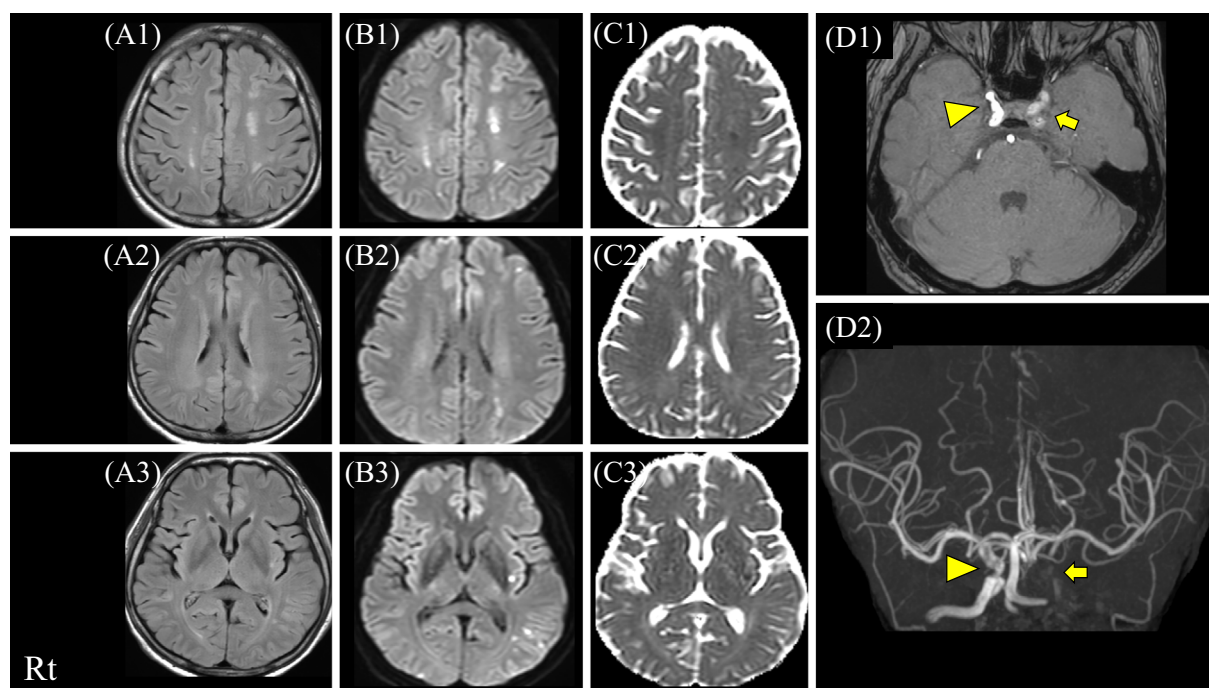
MRI of the brain (axial DWI, ADC, and FLAIR), and MRA performed after admission. (A1-3, B1-3) FLAIR and DWI show hyperintense lesions in the bilateral watershed areas between the anterior, middle, and posterior cerebral artery territories, which are predominantly distributed in the left hemisphere. (C1-3) The ADC values of the lesion are slightly lower in the left hemisphere than in the right. (D1) MRA depicts occlusion in the left ICA (small arrow) and slight stenosis at the siphon of the right ICA (arrowhead). (D2) The left ICA is invisible on reconstruction of MRA images (small arrow). The stenosis of the right ICA is also observed at the siphon (arrowhead). DWI: diffusion-weighted imaging, ADC: apparent diffusion coefficient
